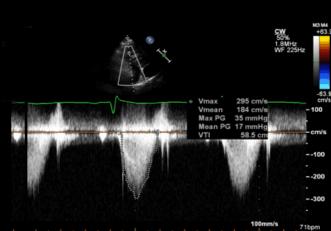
Two-dimensional echocardiogram showed an estimated left ventricular ejection fraction ≥75% and a large vascularized anterior mediastinal mass abutting the aortic root, ascending aorta partially obstructing the right ventricular outflow tract (RVOT) and pulmonary artery.
